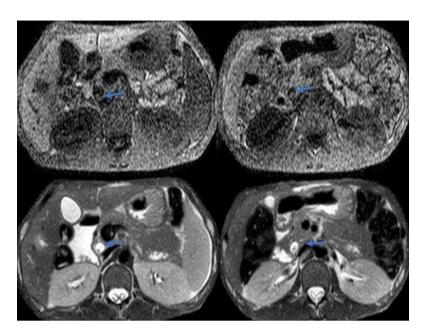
(A-D). MRI -T1W axial images (A, B) show isointense dot surrounded by hypointense bile and T2W axial images (C, D) show hypointense dot with surrounding hyperintense bile within dilated CBD (Eye-glass appearance)- suggestive of Ascaris
